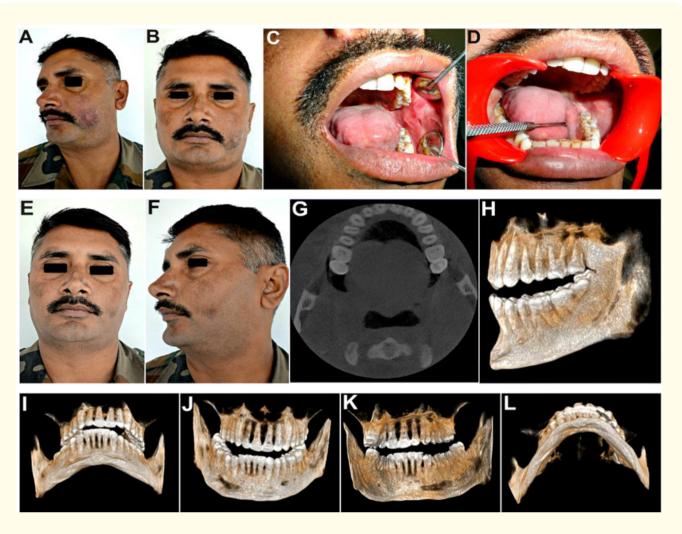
(A, B) One week Postoperative appearance, showing satisfactory resolution of the buccal swelling and closure of the sinus opening. (C, D) Good healing of the intraoral incision site and return of buccal mucosa to its normal colour and consistency, with a visibly patent Stensen's ductal opening through which normal saliva could be expressed. (E, F) Three weeks postoperative appearance, showing a barely perceptible scar of the completely healed extraoral sinus. (G-L) Postoperative CBCT confirming complete elimination of the Stensen's duct sialolith, with no evidence of any remaining fragments or residual concretions.
